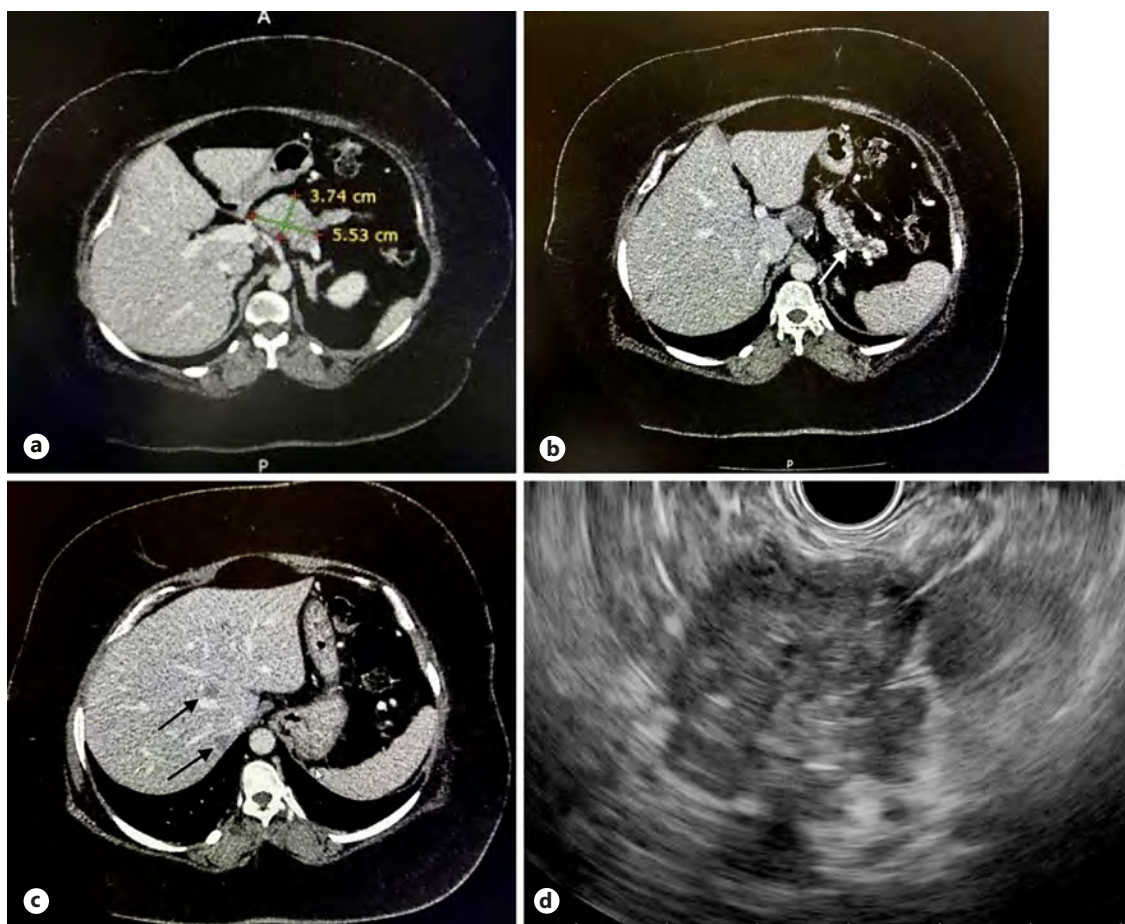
CT showed an ill-defined hypodense lesion at the body of pancreas (a) causing main pancreatic duct dilatation with pancreatic tail atrophy (white arrow, b) and small hypodense liver lesions suggestive of metastases (black arrows, c). An ill-defined hypoechoic lesion at the body of pancreas was visualised on EUS (d).
